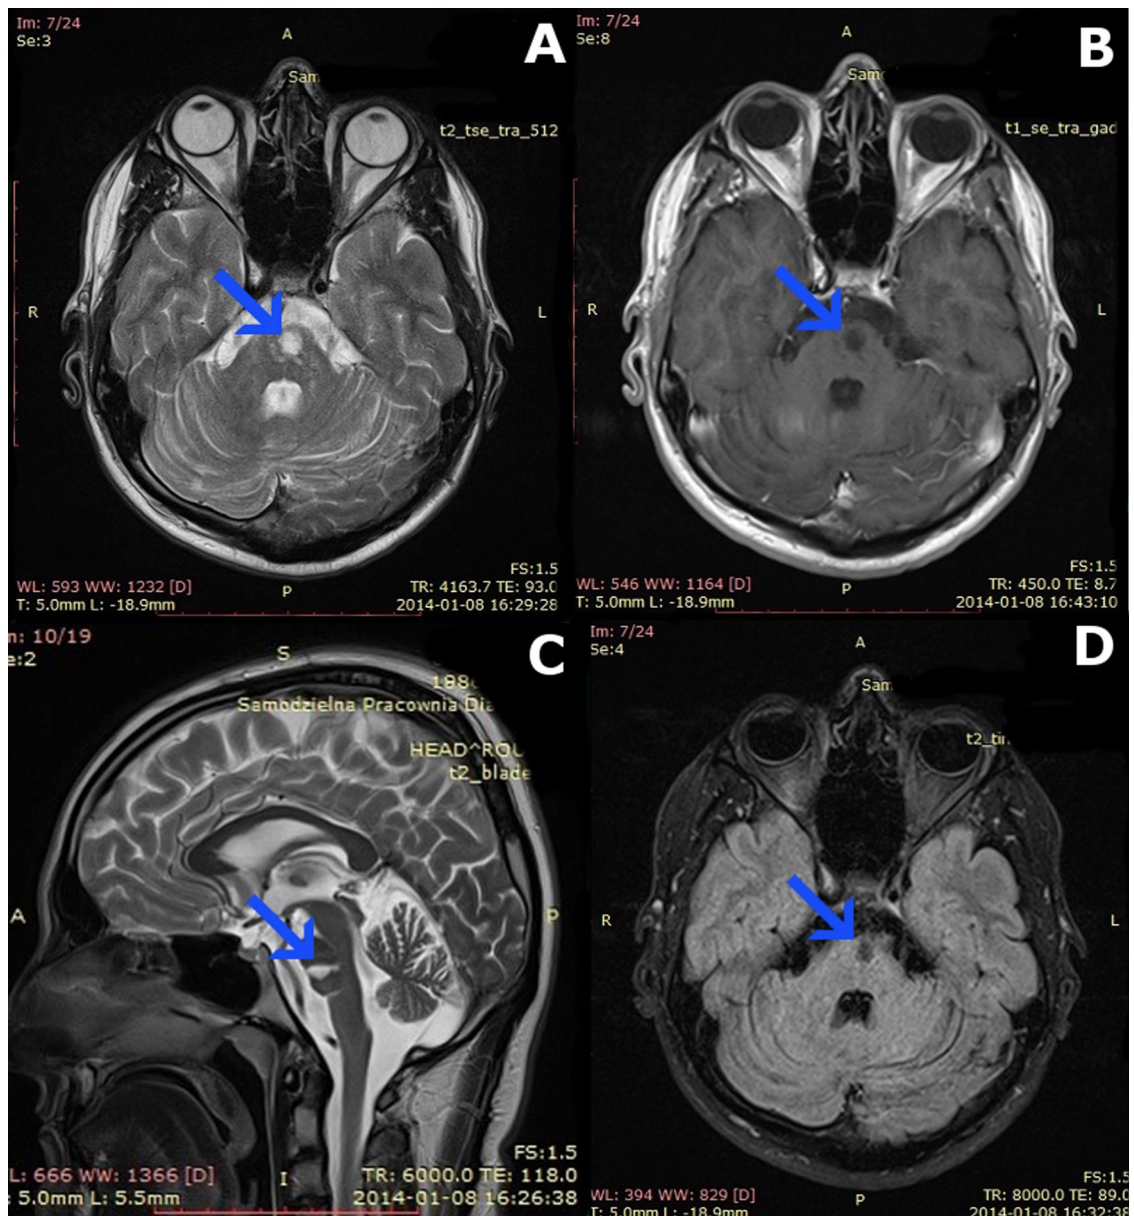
Magnetic resonance imaging (MRI). Control MRI after 22 weeks after ischemic stroke. (A, B, C, D) Post-stroke changes in the brain stem (arrowhead).
